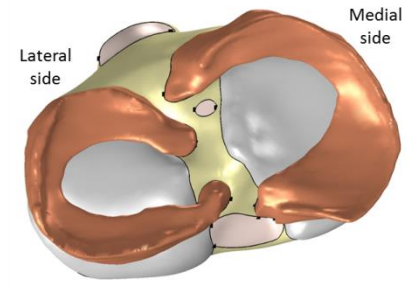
Knee model domains and features developed from segmented MRI data
